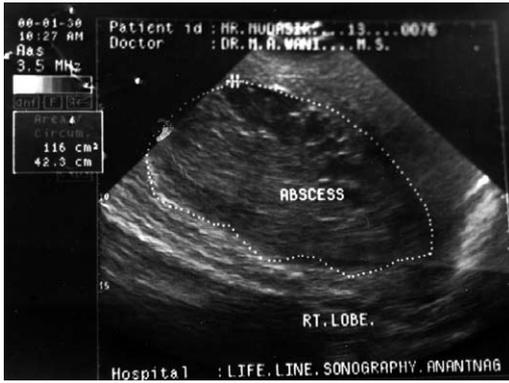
Ultrasonographic picture showing abscess in the right lobe of the liver.
